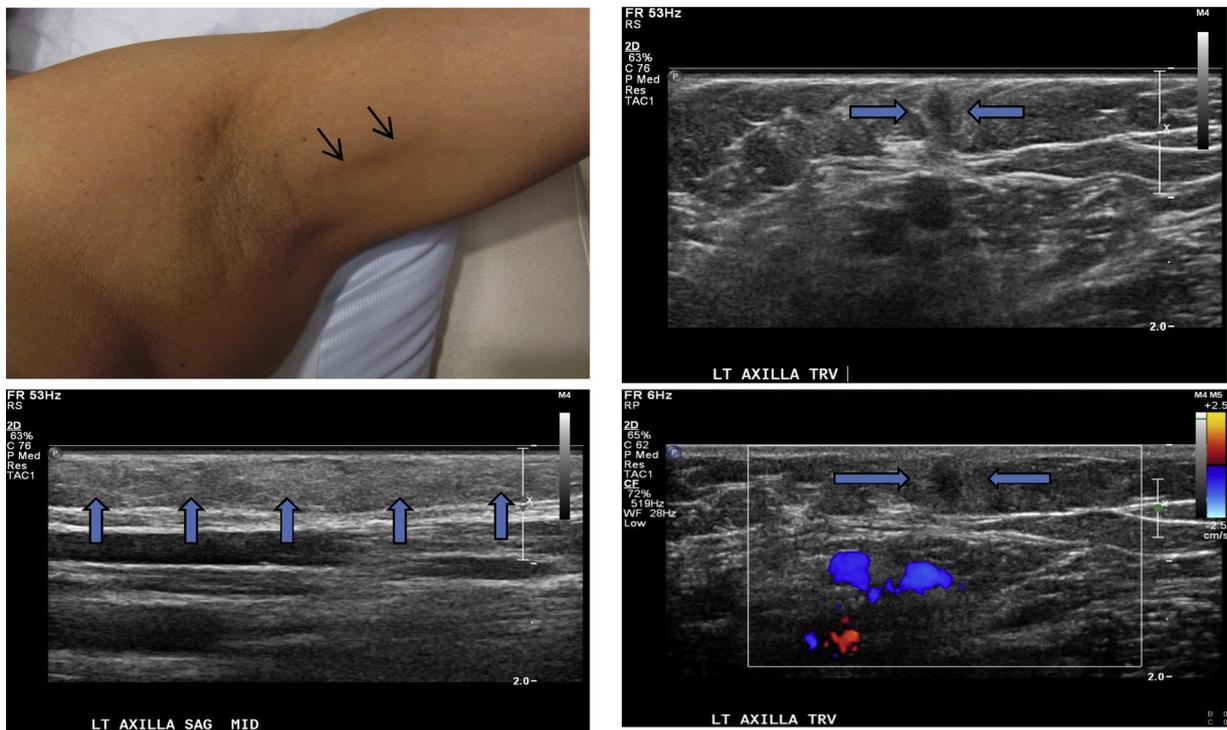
50-year-old woman with visible and palpable cord in the left axilla, 3 months after lumpectomy and sentinel lymph node biopsy for treatment of breast cancer. A: clinical appearance of cord in the axilla, B: transverse ultrasound of cord, showing central hypoechoogenicity and increased echogenicity of surrounding subcutaneous fat, C: sagittal view of cord, showing increased echogenicity of surrounding fat, D: color Doppler image showing no flow in cord.
